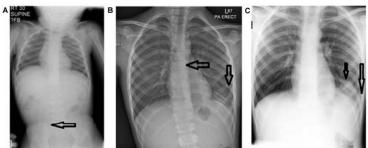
Controlled babygram at 1 year for ingested foreign body (arrow) Fig 1B — Initial chest radiograph showing scoliosis concave to left and streaky appearance of left lower segment
